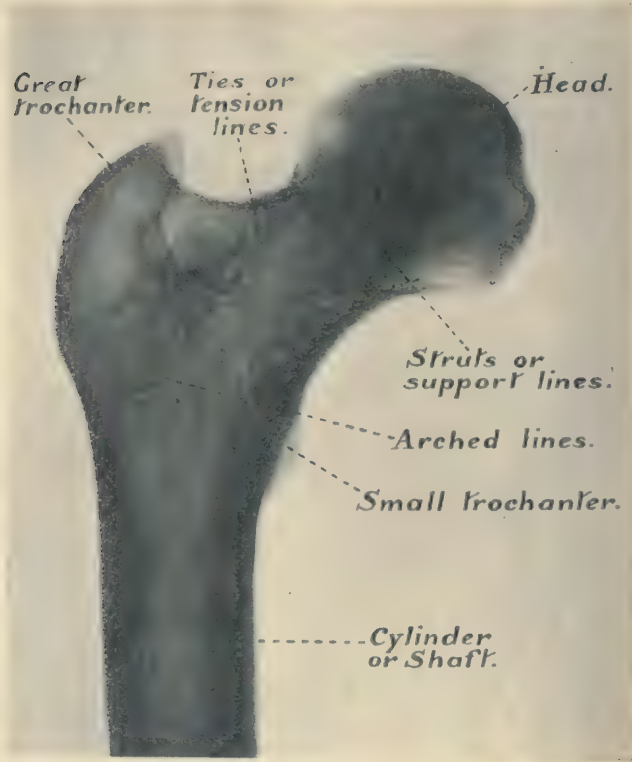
An X-ray picture to show the design or construction of the upper end of the thigh-bone.
